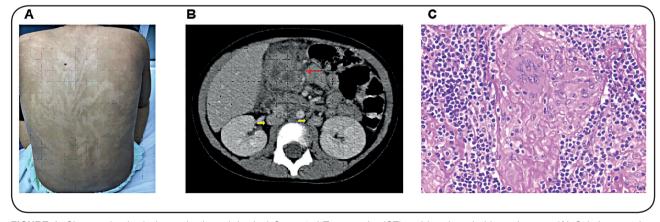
Changes in physical examination, abdominal Computed Tomography (CT) and lymph node biopsy images. (A) Colorless patches following Blashchko's lines in the torso. (B) Contrast enhanced upper abdomen CT scan (portal phase). The yellow arrows indicate a homogeneous retroperitoneal interaortocaval lymphadenopathy. The red arrow indicates a mesogastric mass with a necrotic/ liquefied center with densification of adjacent fatty tissue. (C) - Right axillary lymph node biopsy demonstrating characteristic noncaseating granuloma with lack of central necrosis, multinucleated giant cells with histiocytes and surrounding lymphocytes.
